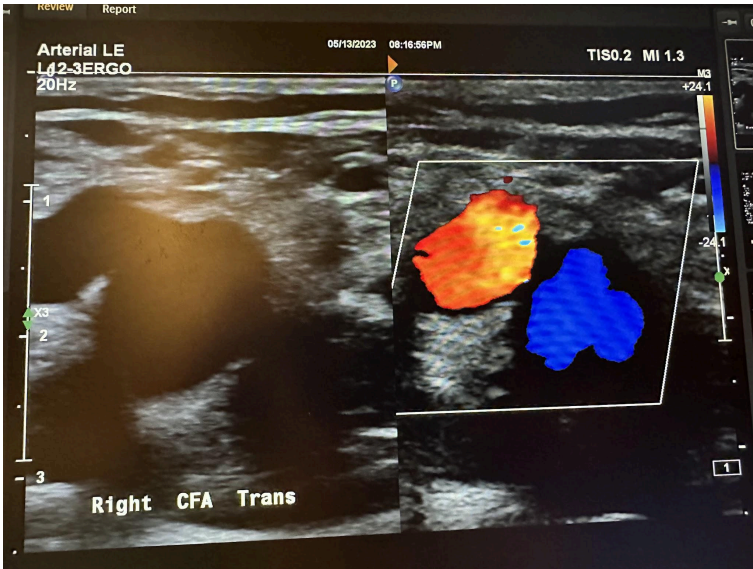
Side-by-side transverse images of the right common femoral artery without color Doppler and with color Doppler.
